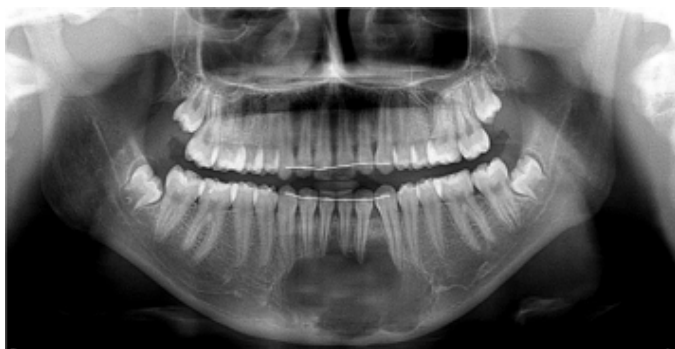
Panoramic radiograph showing a large unilocular radiolucent lesion at anterior mandible.
